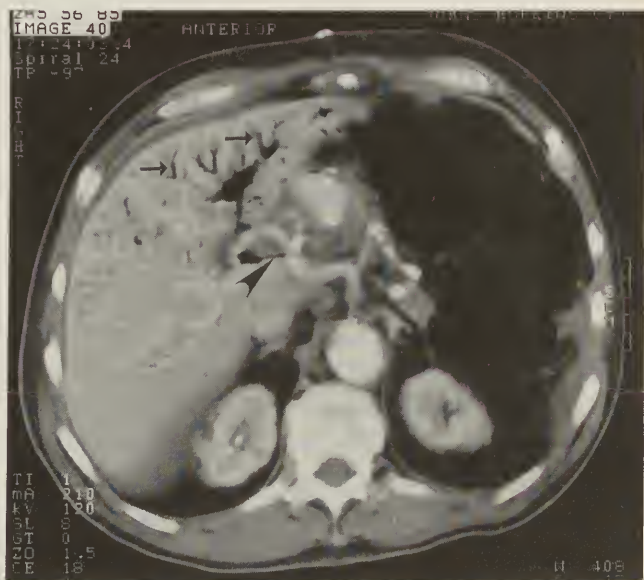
Abdominal CT demonstrating extensive portal venous air in an antidependent location within the liver (arrows) and also tracking along the ventral portion of the portal vein into the portal venous confluence (arrowhead). Cuts immediately inferior to this position demonstrated air present within the superior mesenteric vein.
